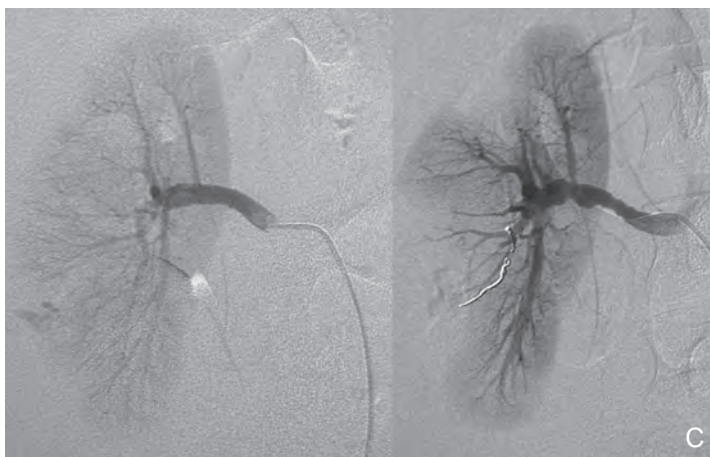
A, Computed tomography showing left post-traumatic arteriovenous fistula. B, Angiogram showing left post-traumatic arteriovenous fistula. C, Angioembolization of right renal laceration: arteriography demonstrating active arterial bleeding. Coil embolization was used to control bleeding. Note the presence of the coil and large, triangular area of infarct.
